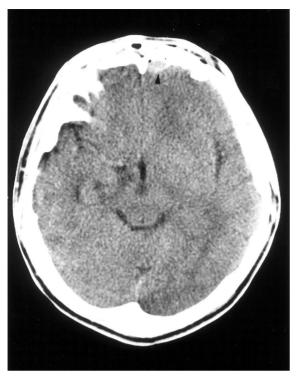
Brain CT scan of case 1. Minimal subdural hematoma (arrowhead) and subarachnoid hemorrhage over left frontal lobe without mass effect were noted.
